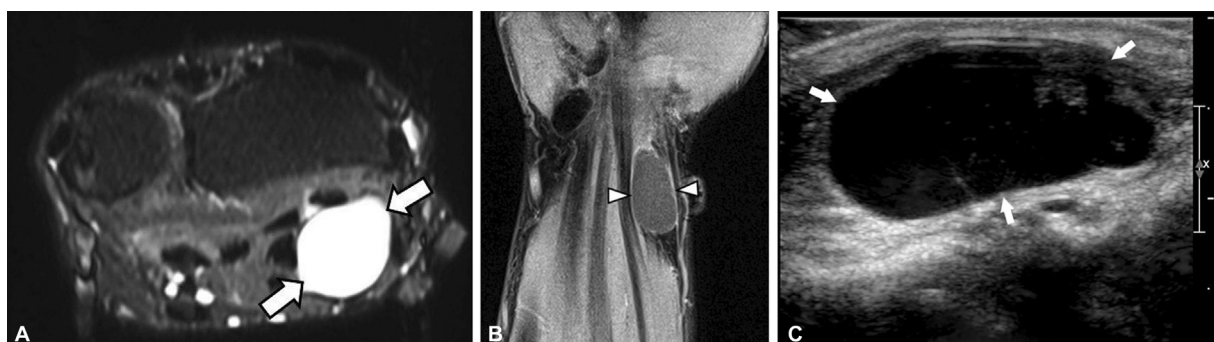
A 50-year-old woman with wrist mass and hand discomfort. (A) Axial T2 fat-suppressed and (B) coronal axial T1 fat-suppressed postcontrast magnetic resonance (MR) images show a well-circumscribed T2 hyperintensity mass (arrows) with thin peripheral enhancement (arrowheads) compatible with a synovial cyst. (C) Ultrasound image shows an anechoic mass (arrows) with increase through transmission.
